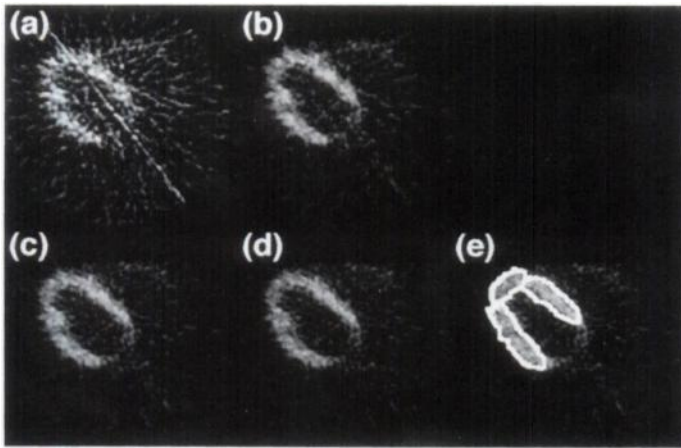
FDG emission images showing only the myocardium and area around it. Images (a)–(d) are processed with 2-, 6-, 11-, 20-mm FWHM transmission smoothing, respectively. Image (e) shows an example of ROIs drawn over the lateral, anterior and septal regions of the LV.
